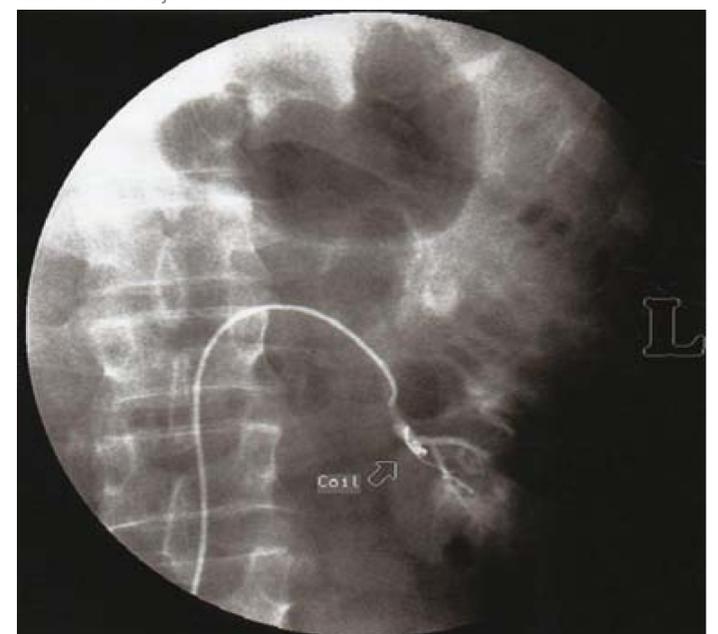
X-ray showing the coil in the kidney-ureter-bladder area after angioembolization.
